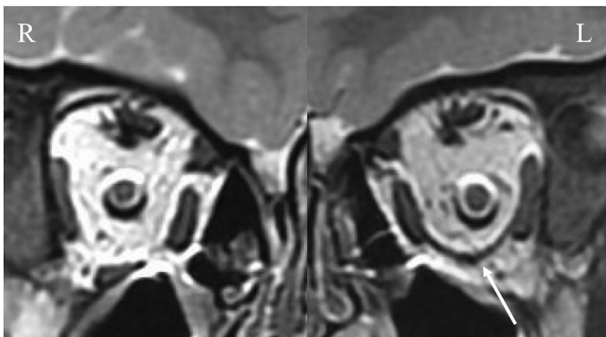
T2-weighted coronal magnetic resonance images of the right (R) and the left (L) eye, showing abnormality of the left inferior rectus muscle (arrow).
